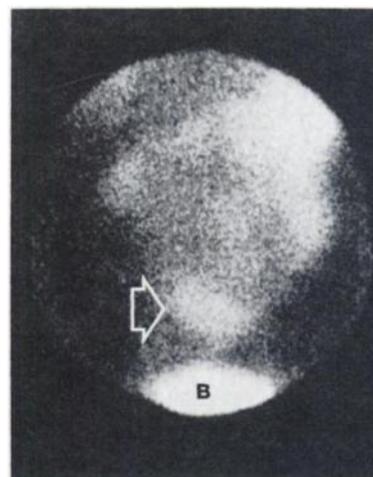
Abdominal scintigram at 60 min after pertechnetate injection, showing prominent midline activity in lower abdomen (arrow). Ectopic gastric mucosa was found to exceed the limits of a Meckel's diverticulum, spreading into the adjacent bowel wall. B = urinary bladder.
